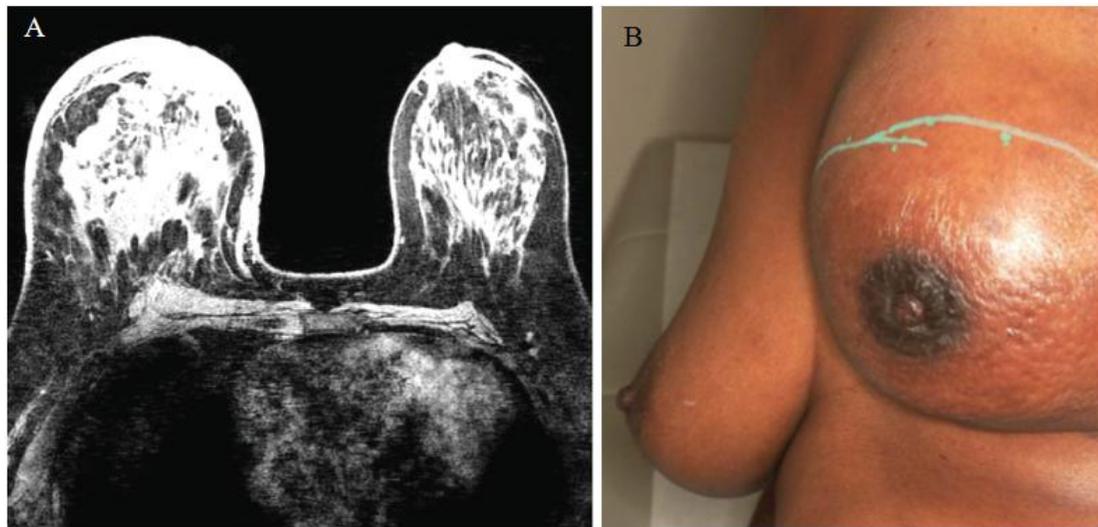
Inflammatory Breast Cancer Presentation (A) MRI of IBC (left breast) [adapted from Kidwell, 2007]. (B) Many of the classic symptoms of IBC: nipple retraction, peau d’ orange, swelling and thickening of the skin, are visible [Kidwell, 2007].
